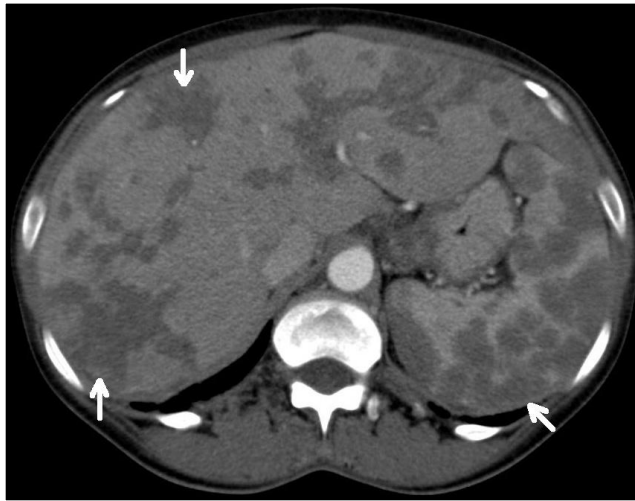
CT abdomen with contrast. Arrows indicate irregular hypoattenuating masses in the liver and spleen.
